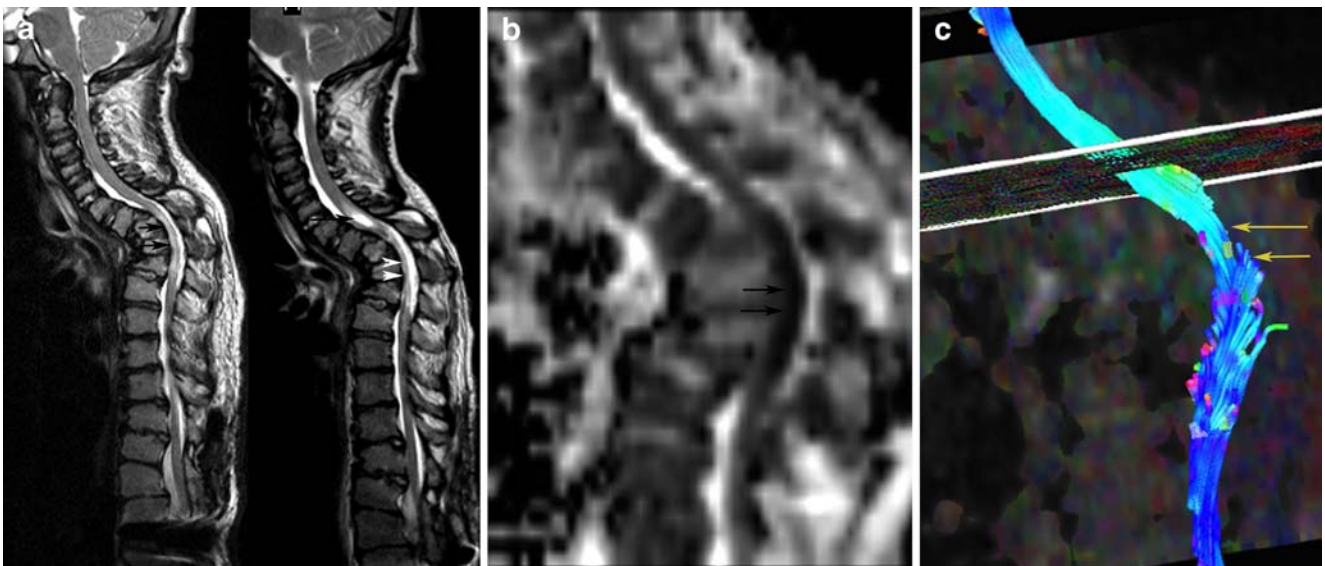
Post-operative ischemia. a On the first magnetic resonance image (MRI) (*left*) there is hyperintensity in the spinal cord (*black arrows*), which is better seen on the control MRI (*right*) with partially cystic formation (*black arrow*) and atrophy (*white arrows*). b There is
